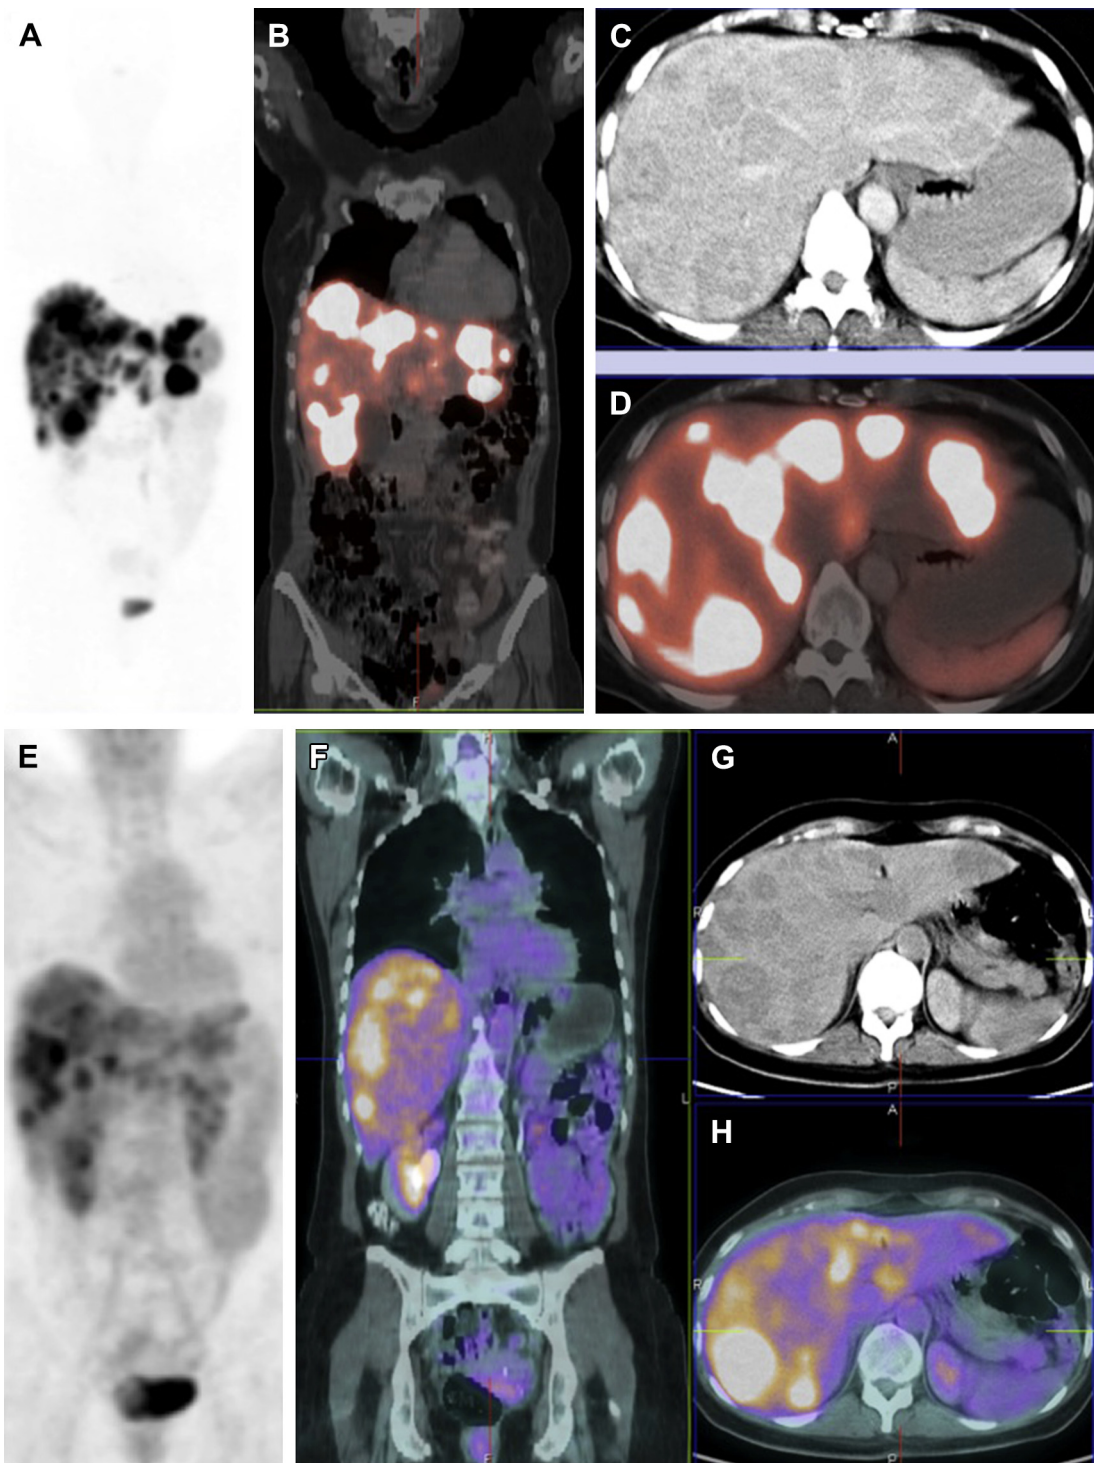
A 45-year-old female patient with a poorly differentiated (G3), nonfunctional neuroendocrine carcinoma of the pancreas with extensive liver metastases. The proliferation rate (Ki-67) of the tumor was 40% with expression of chromogranin A, synaptophysin, and CD 56. She had undergone chemotherapy with Carboplatin and Etoposide, however, with poor results and progressive leucocytopenia. Both ^{68}Ga -DOTATOC SSTR PET/CT as well as ^{18}F -FDG PET/CT were performed to assess the option of PRRT and to evaluate the prognosis, respectively. Despite a high grade of the tumor, there was a very high SSTR expression by the disseminated hepatic metastases, with an SUV_{max} of 71.7. No extrahepatic metastases were seen. Notably, ^{18}F -FDG PET/CT showed a complete matched finding with glucose hypermetabolism of the liver metastases (SUV_{max} of 9.9). With high SSTR expression by the liver metastases, the indication for PRRT was confirmed, which was further demonstrated by the high uptake of ^{177}Lu -DOTATOC (after the first PRRT cycle) in the metastases. ^{68}Ga -DOTATOC PET/CT: (A) MIP; (B) fused coronal PET/CT; (C) transverse CT; (D) fused transverse PET/CT. ^{18}F -FDG PET/CT: (E) MIP; (F) fused coronal PET/CT; (G) transverse CT; (H) fused transverse PET/CT. ^{177}Lu -DOTATOC whole-body planar image post-therapy: (I) anterior view; (J) posterior view.
